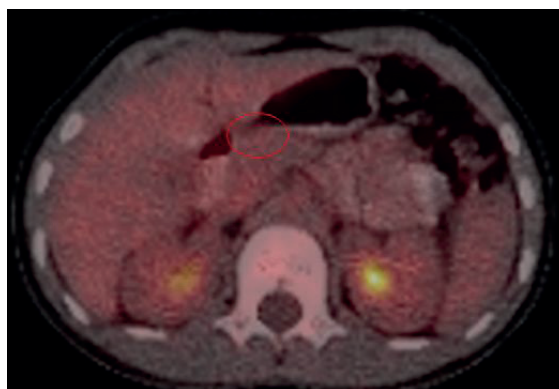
PET/CT presenting absence of metabolic activity at the site of intrapancreatic mass.
